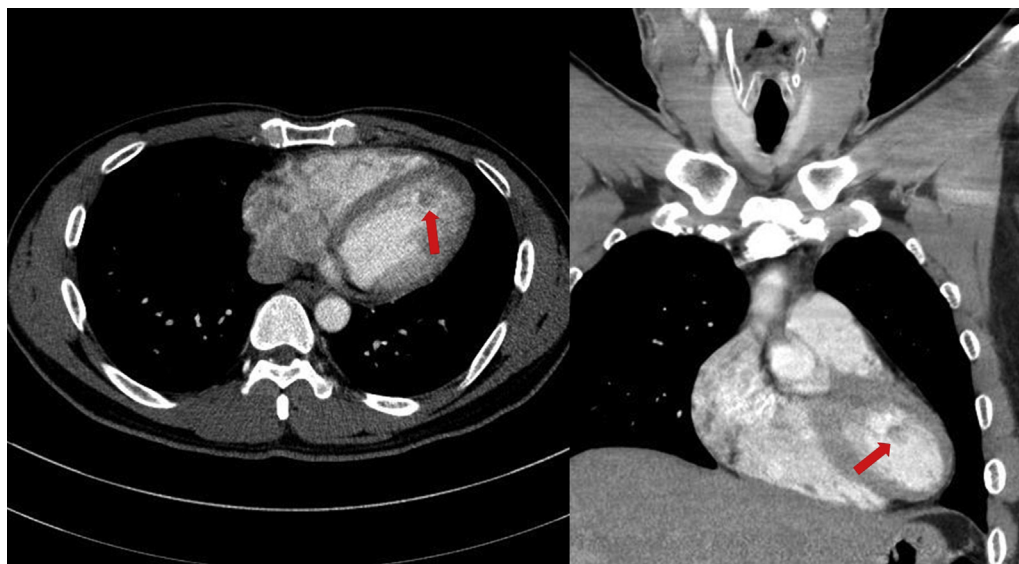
Chest CT shows the small, focal-enhanced mass attached to the left interventricular septum in multiple views (arrows). CT, computed tomography.
